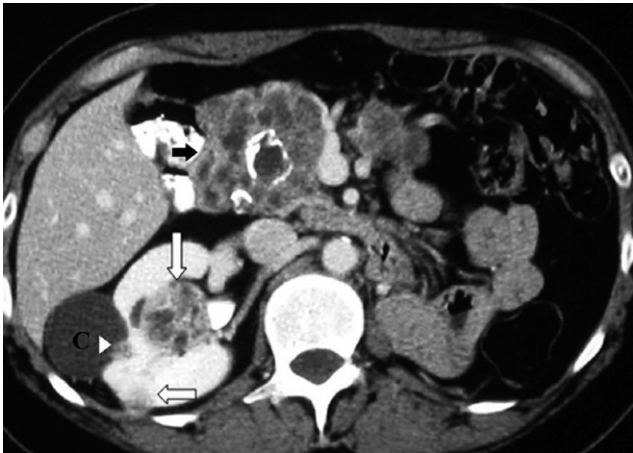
Clear cell RCCs in a patient with VHL syndrome. Contrast-enhanced CT shows 2 hypervascular, solid RCCs in the right kidney (arrows) and a large exophytic cystic RCC (C) with an enhancing mural nodule (arrowhead). A pancreatic head serous cystadenoma (black arrow) is also noted.
